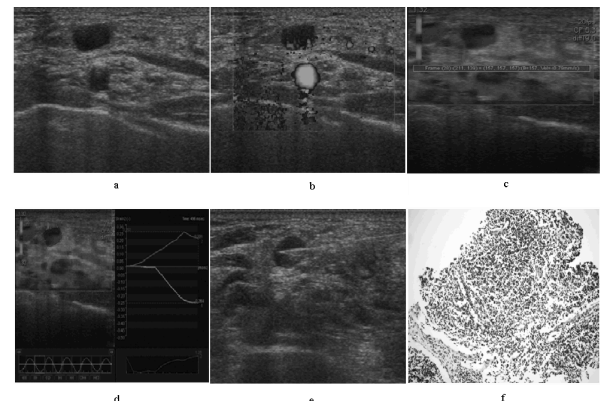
Figures Obtained from a 40-year-old Woman with Left Supraclavicular Fossa Enlarged LN. (a, b) sonogram obtained from conventional ultrasound; (c, d) on the elastogram, the proportion of blue areas in this LN was more than 50%, so it was scored 3 point. But the blue areas in the LN were light blue, the SR was only 1.33; (f, g) the LN was undergone a biopsy with ultrasound-guided, and the pathology of this LN was reactive hyperplasia. 4 scoring method was misdiagnosis, but SR was correct diagnosis
